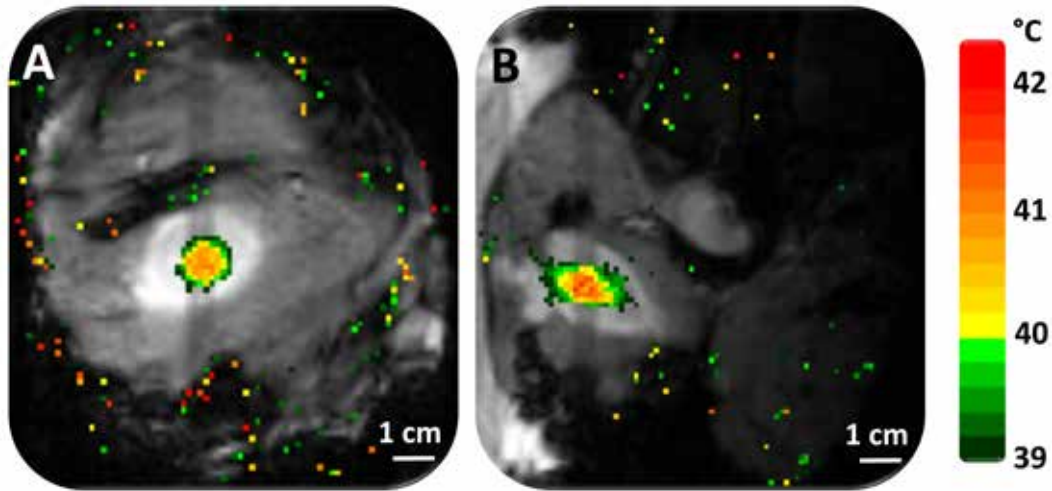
PRFS-based temperature mapping for MR-HIFU mild hyperthermia: A) Coronal MR image, B) Sagittal MR image. Temperature maps (color scale) are overlaid on dynamic magnitude images (gray-scale), showing typical temperature distribution during HIFU heating. Target temperature range was 40.5–41 °C. Heating location corresponds to target region 4 in figure 4.1. Image reproduced from Publication II with permission from AAPM.
